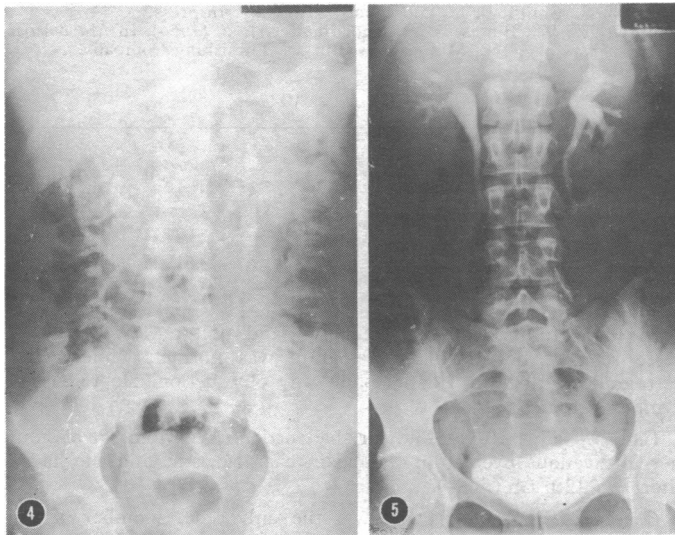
Case 3. Short left 12th rib. FIG. 5—Case 4. X-ray picture showing six lumbar vertebrae.
